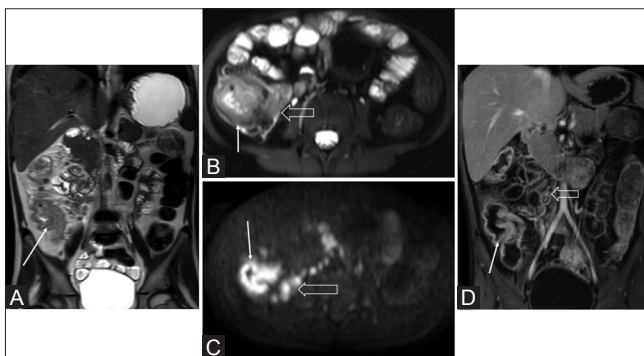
(A-D): Ileocecal TB. T2-weighted MRE images (A and B) showing wall thickening that is hyperintense involving the ileocecal region (thin arrow) with enlarged regional lymph nodes (outlined arrow). The wall thickening and enlarged nodes show diffusion restriction on diffusion weighted b 800 image (C) and hyperenhancement on postgadolinium image (D) along with necrotic enlarged lymph nodes
